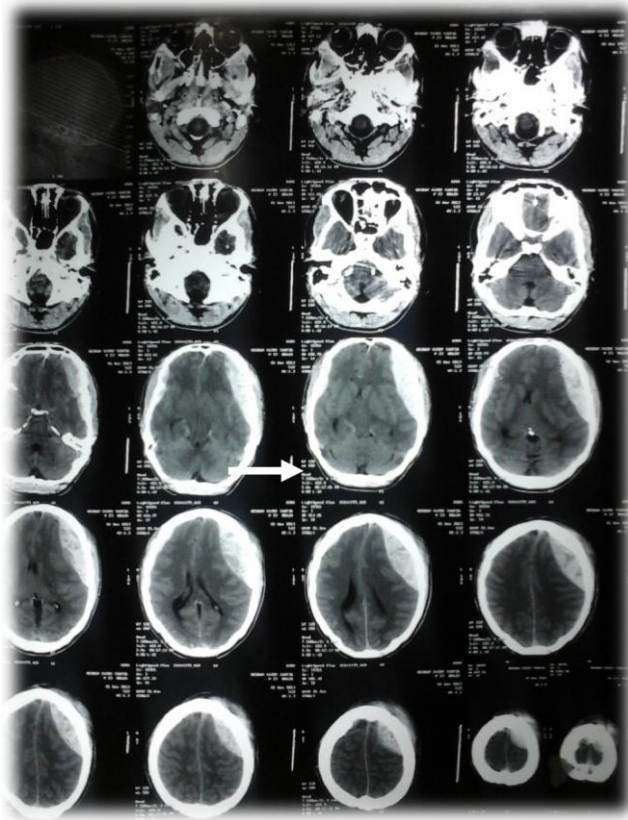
Pre-operative CT brain of Case 4
